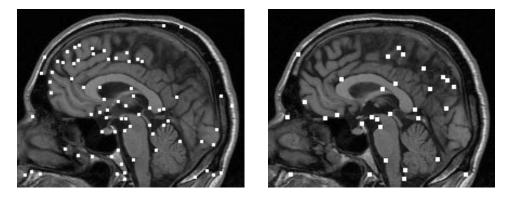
Landmark candidates: Application of a 2D 'corner' detector (left) vs. a 3D extension (right) on a 2D and 3D MR image, resp.
